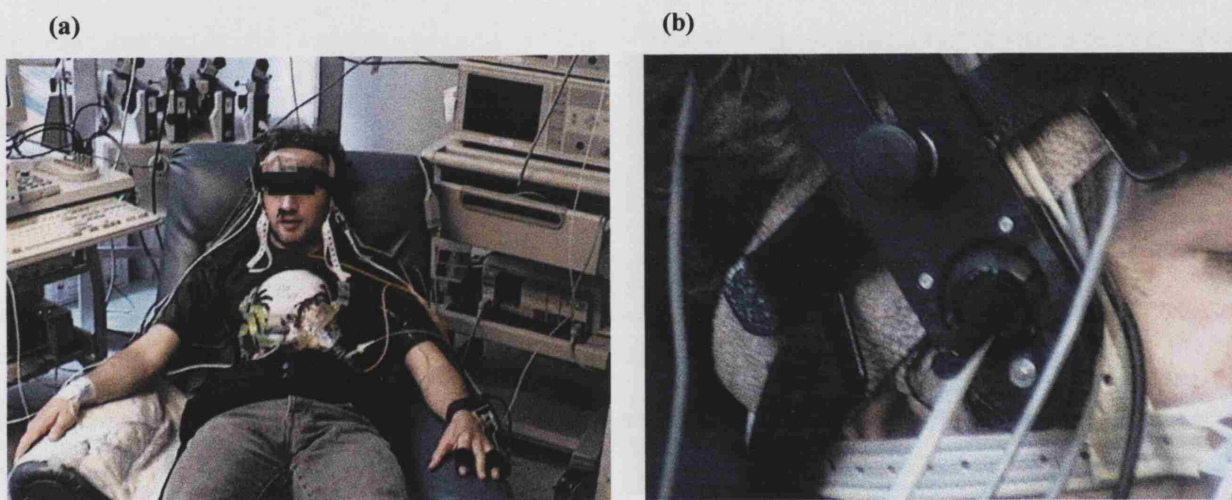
Pictures of the experimental set up. (a) The set up of the monitoring systems on a volunteer. (b) The position of the transcranial Doppler probe.
